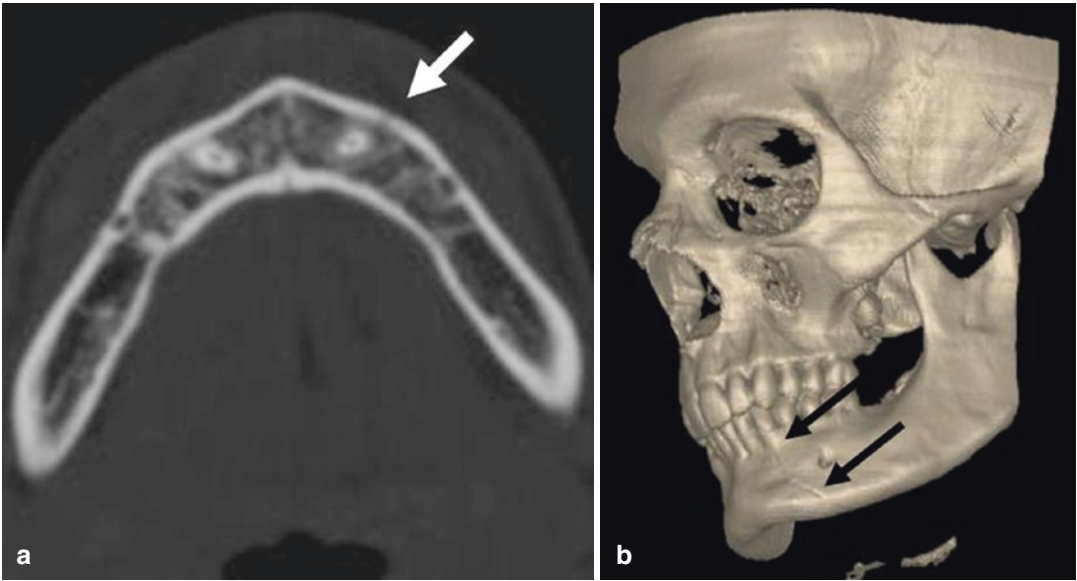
CT axial scan (a, white arrow) and 3D reconstruction (b, black arrows): fracture of the left mandibular ramus
